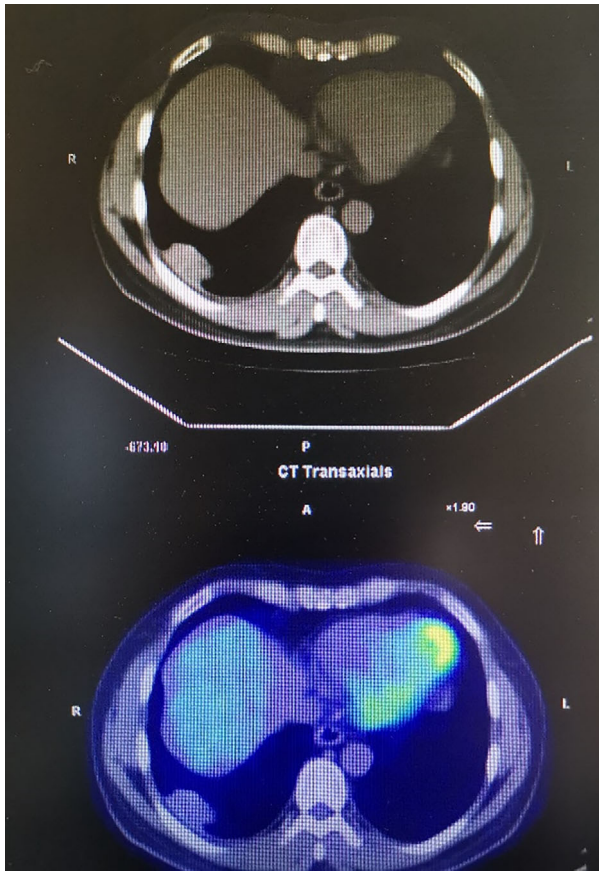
Computed tomographic scan reveals a subpleural mass with dystrophic calcification in the right lower thoracic cavity
